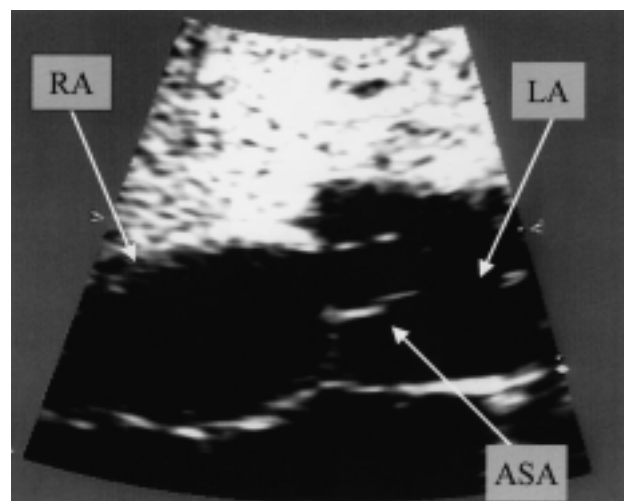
Two-dimensional echocardiography in the 4-chamber view of the atria of a fetus with an atrial septal aneurysm bulging (white arrows) into the left atrium. Abbreviations as in figure 1.
